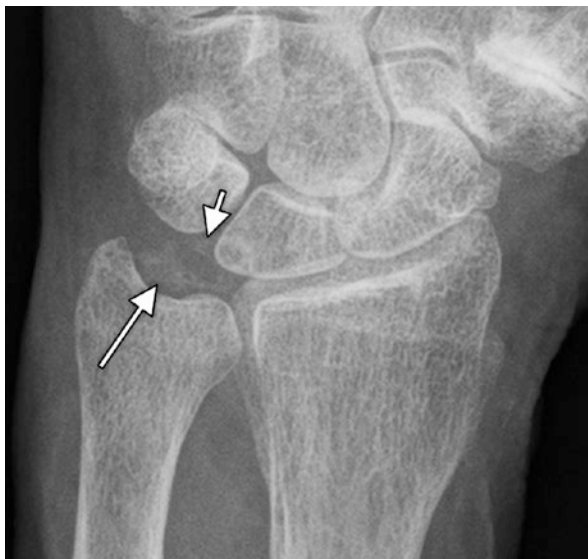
An AP radiograph of the wrist of a 93 years old male demonstrating chondrocalcinosis of the triangular fibrocartilage ligamentous complex as well as proximal migration of the scaphoid bone with advanced osteoarthritis changes with the adjacent radius resulting from a tear of the scapho-lunate ligament. These findings are all characteristic of CPPD
